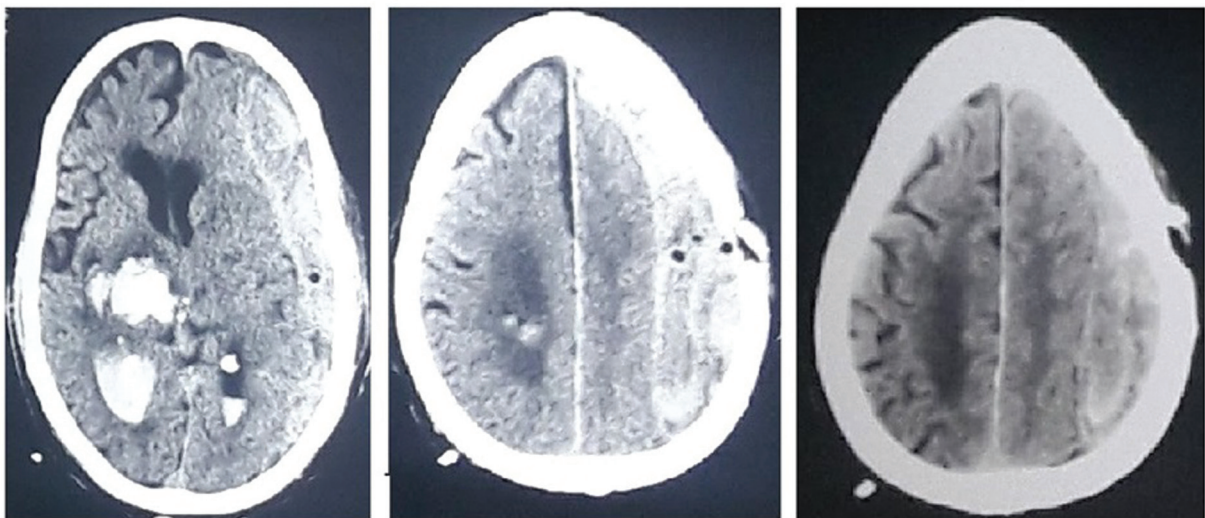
Noncontrast computed tomography (CT) head showing left side thick subdural collection with burr hole defect and right capsuloganglionic bleed with intraventricular extension.
